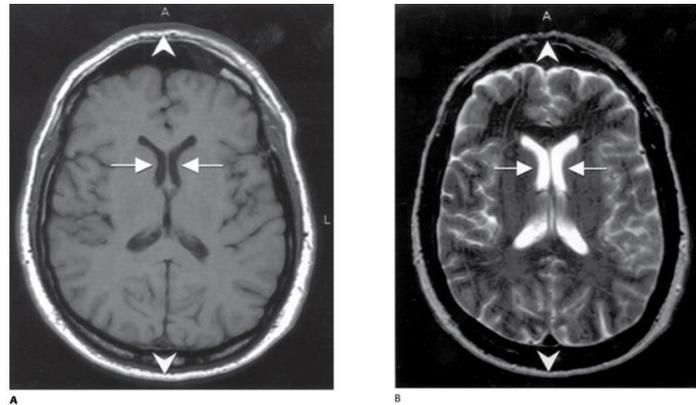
and 1B: MRI T1 and T2 Sequences
